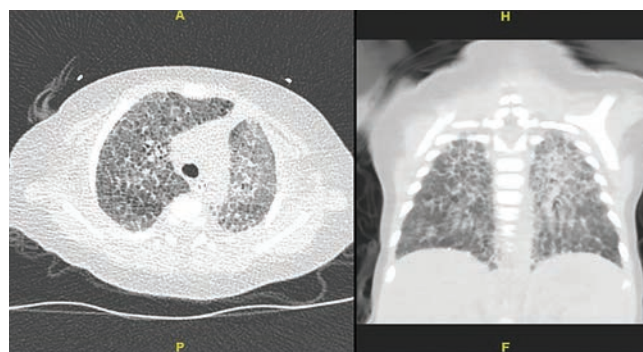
High-resolution computed tomography of the thorax (non-contrasted). Axial and coronal views show ground glass changes and interstitial thickening in upper, middle and lower lobes (especially over the left side).
